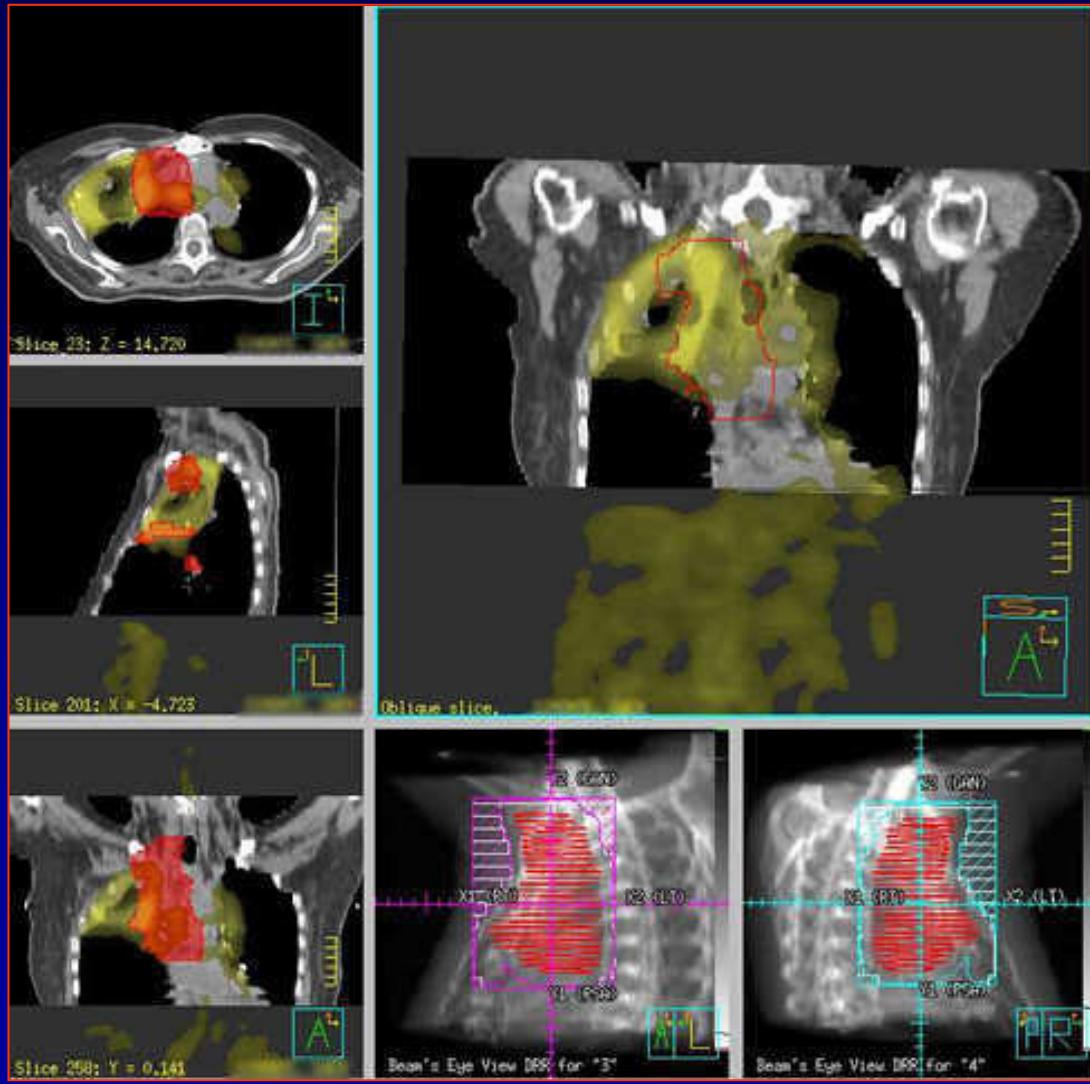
FDG-PET-CT fusion images of patient with [^{18}F]FDG negative atelectasis. Pink structure: GTV derived from PET (source-background algorithm). Red contour: GTV derived from CT.
